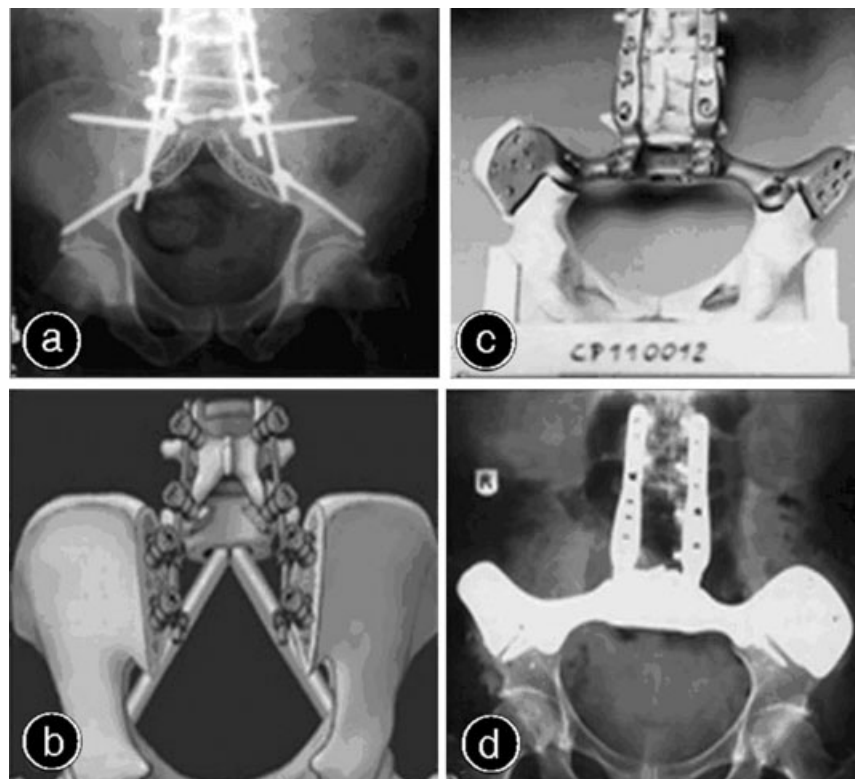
(a): Anteroposterior radiographs and (b) three-dimensional model obtained after implantation of the improved Galveston L-rod. (c): Three-dimensional model of patient's pelvis with the special prosthesis, and (d) postoperative radiograph showing well-incorporated grafts at the pelvic sites and unchanged stable position of the prosthesis.
